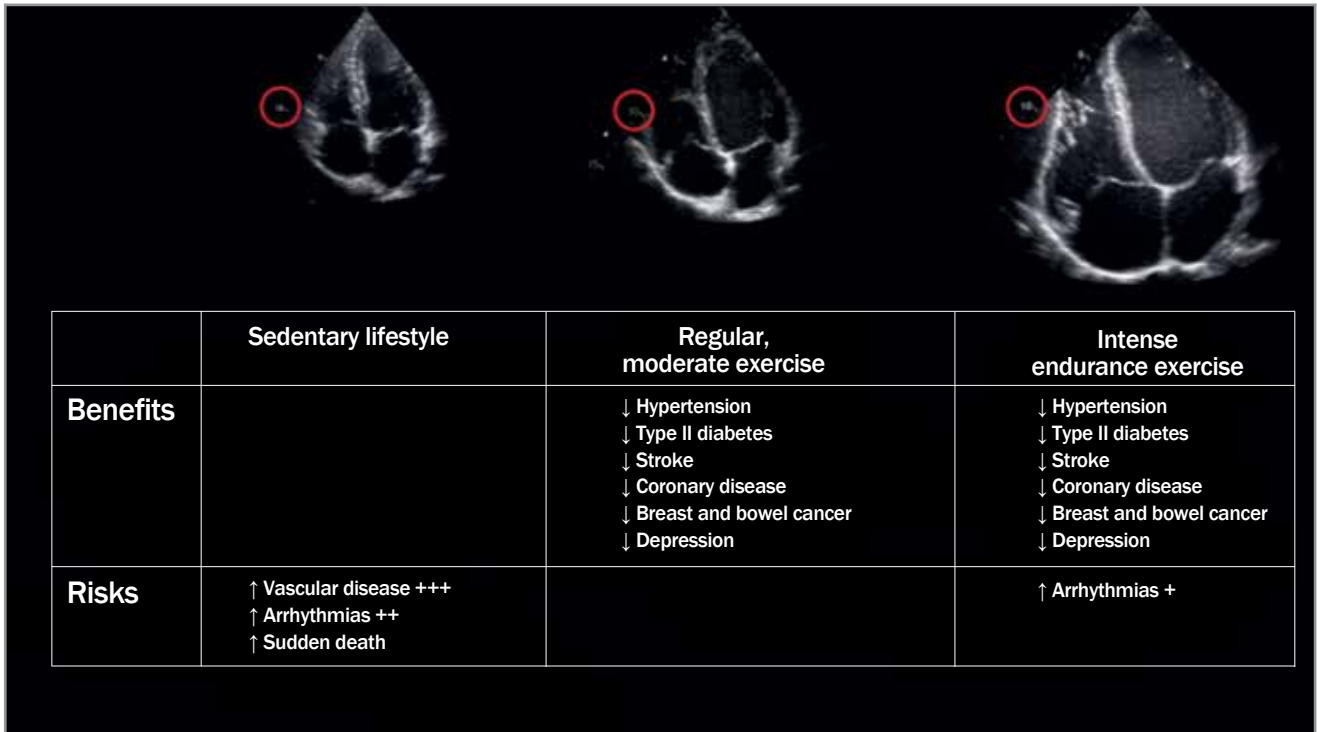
Benefits and risks of exercise. There are substantial health benefits associated with regular exercise compared with a sedentary lifestyle. These benefits are mostly maintained in endurance athletes; however, there may be a small increase in some arrhythmias. This small increase in arrhythmias may relate to the profound changes that can occur in cardiac structure in response to exercise training. The red circle in the images highlights the 1.0 cm depth marker on ultrasound, which has been used to approximately scale the cardiac echocardiographic images. Put simply, the athlete's heart can increase three- or four-fold the size of nonathletes.
